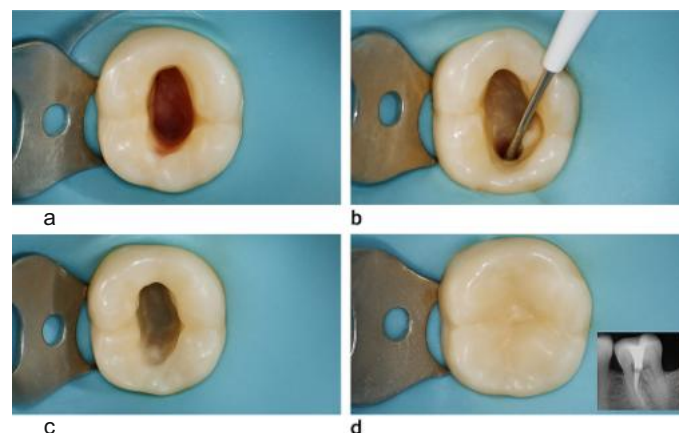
Partial pulpotomy in apexogenesis using MTA-(a) initial pulp exposure, (b) hemostasis, (c) placement of bioactive material, (d) final restoration with postoperative radiograph.
